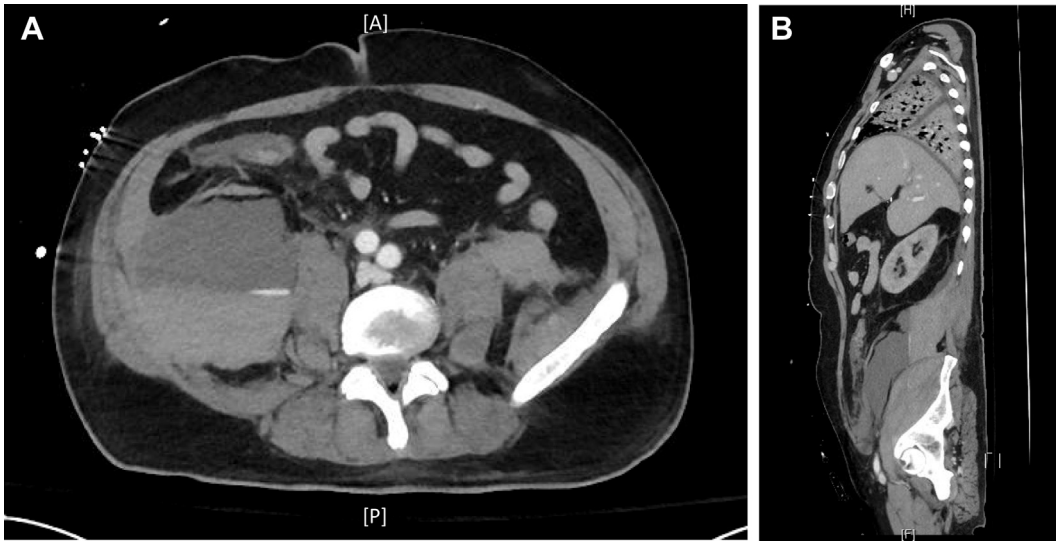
CT images of the patient's abdomen. A, Axial cut at the superior portion of the iliac wings; B, sagittal cut. A = anterior; F = foot; H = head; P = posterior.
